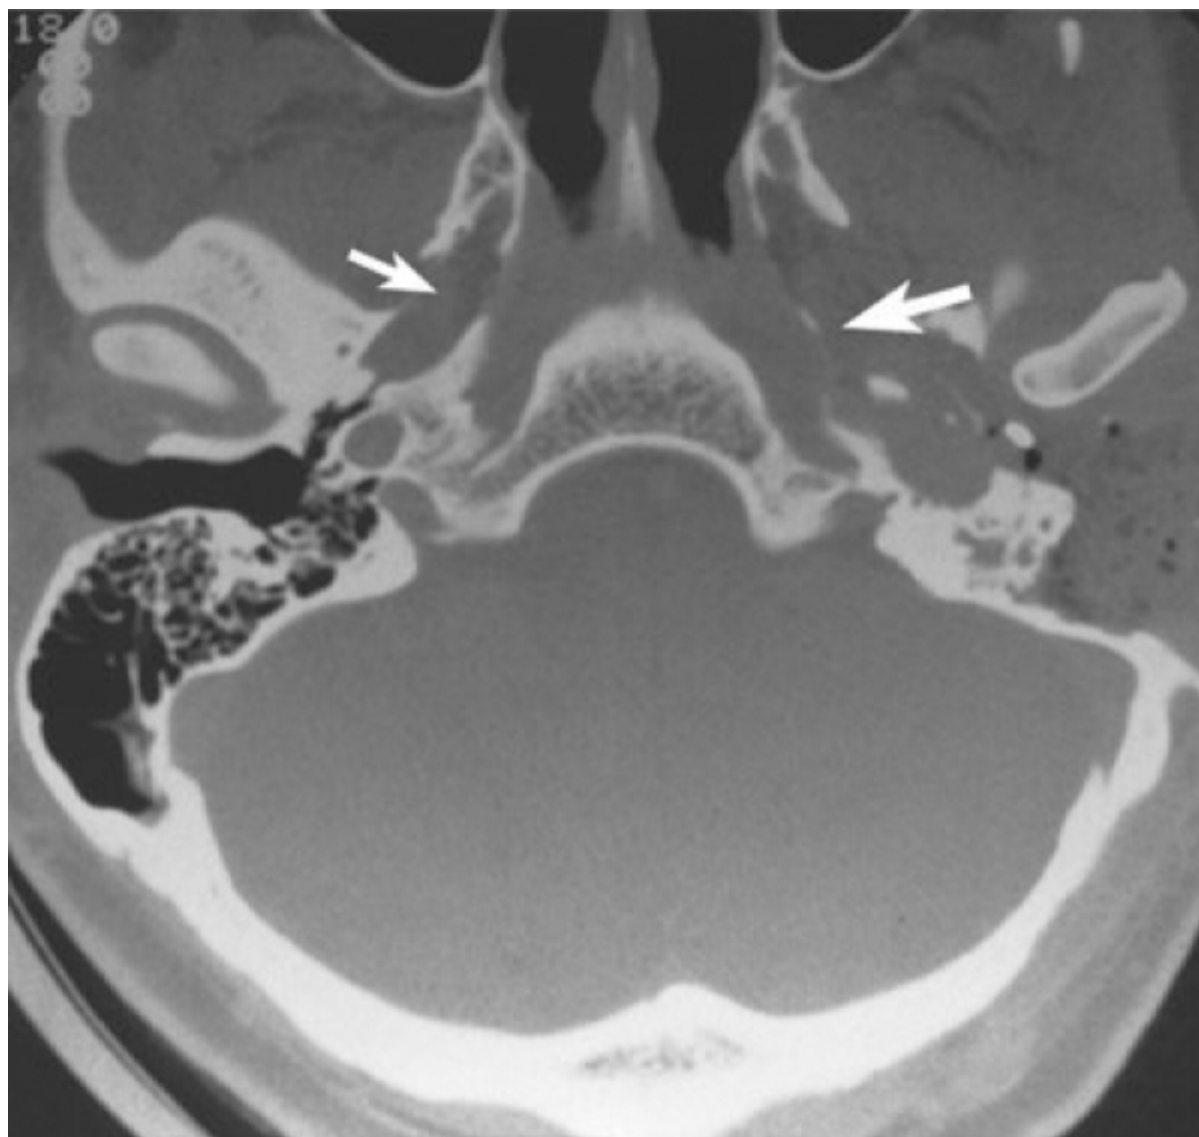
High-resolution computed tomography scan showing a posttraumatic pseudoaneurysm (*large arrow*) of the internal carotid artery. (*Small arrow*, normal carotid.)
